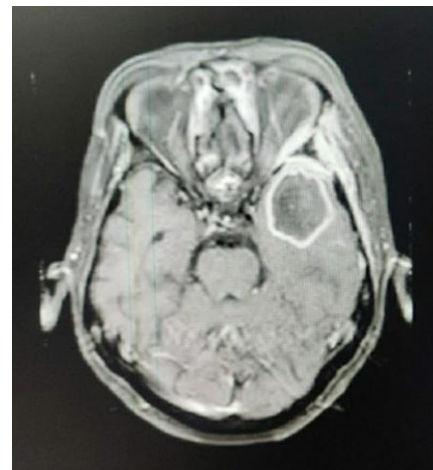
MRI showing temporal lobe abscess.
